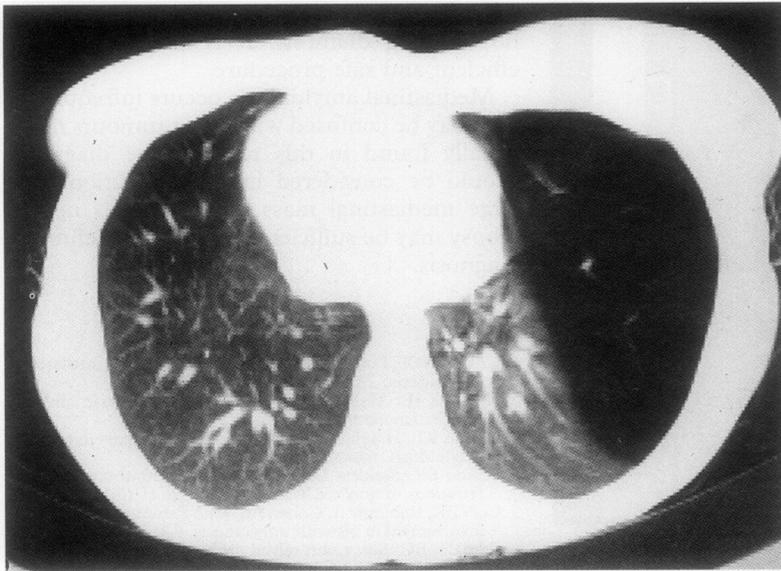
Computed tomographic scan of the chest showing hyperlucent left upper lobe. The mediastinum is shifted toward the right.
